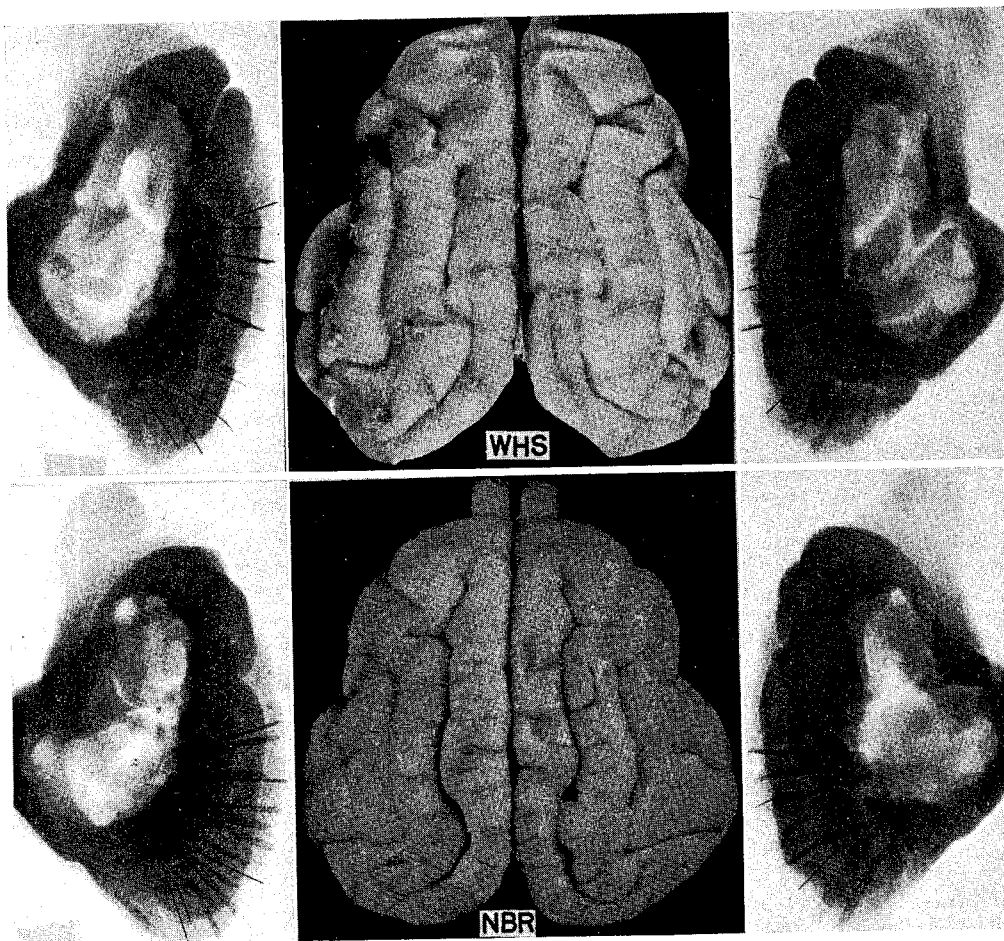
Surface and X-ray views of fixed brains of *W/hs* and *Nbr*. Not all inserted plates are visible at surface. X-ray views show only thicker of mica plates and/or those viewed edgewise.
